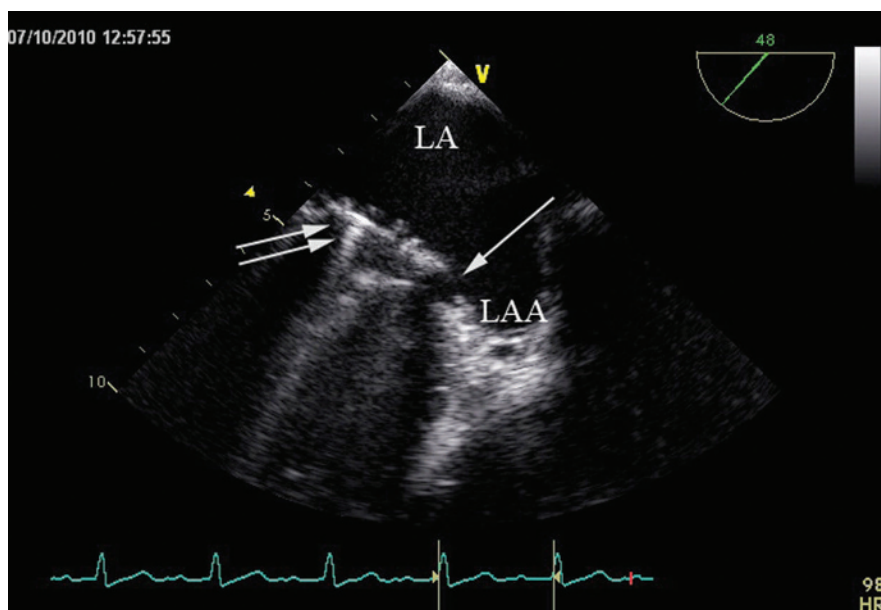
Sample transesophageal echocardiographic image. The prosthetic mitral valve implanted in mitral orifice (double arrow) with dehiscence in lateral part of mitral annulus (single arrow). LA, left atrium; LAA, left atrium appendage.
